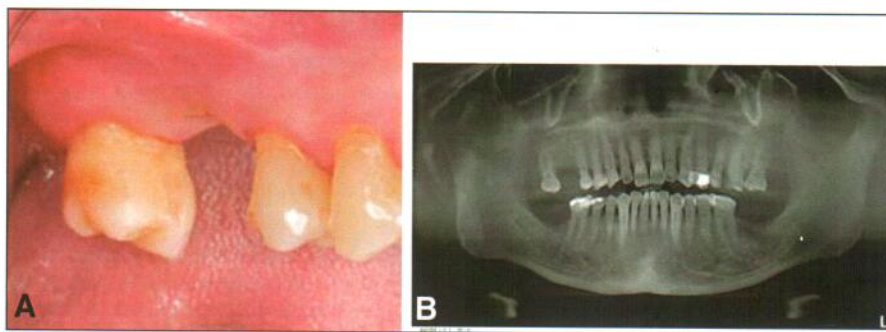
Baseline information of upper right first molar No. 3. A, Intraoral image. B, Radiographic image.
